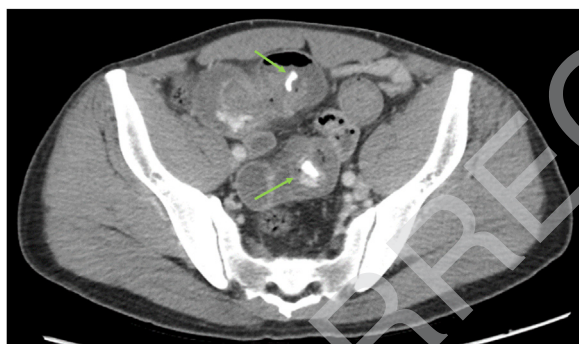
Computed tomography abdomen/pelvis showing two curvilinear radiopaque densities measuring approximately 1.5 cm (green arrows).
